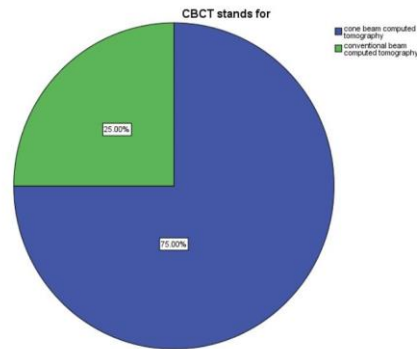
Pie chart shows the knowledge about for the question CBCT stands for. 75% said that CBCT stands for cone beam computed tomography and 25% said that CBCT stands for conventional beam computed tomography. Blue indicates cone beam computed tomography and green indicates conventional beam tomography.
